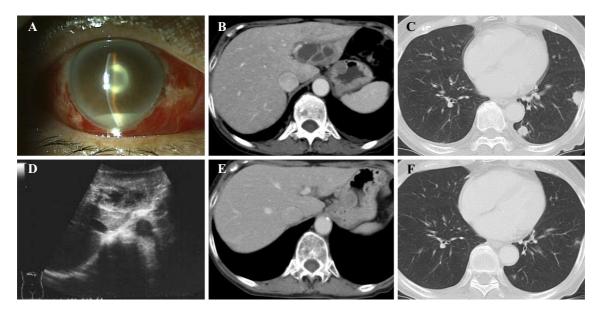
The right eye findings in case 1. A: Grossly, the right eye is slightly erythematous with slight swelling of the eyelid. B: Abdominal CT shows a 50-mm multilocular mass on segment 2 of the liver. C: Chest CT shows multiple lung nodules. D: US shows an isoechoic mass with a hypoechoic multilocular mass on segment 2 of the liver. E, F: A month after discharge, CT shows improvement of the liver abscess and lung nodules. CT: computed tomography, US: ultrasound
